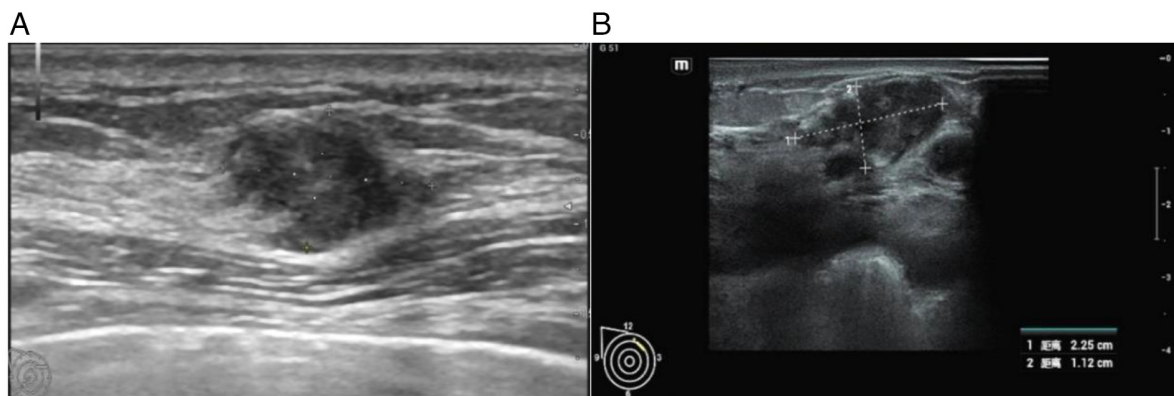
Color Doppler ultrasound results. (A) June 2024 Breast color Doppler ultrasound: Hypoechoic area of right breast, with unclear boundary and irregular shape. (B) August 2024 Breast color Doppler ultrasound: Blurred edge, irregular shape, blood flow signals around.
